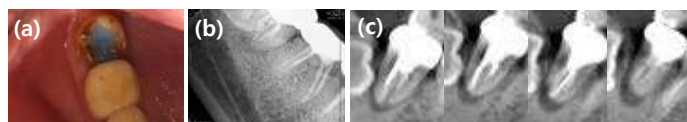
(a) initial intra-oral photograph (b) initial periapical radiograph before the gold crown was exfoliated (c) initial cone-beam computed tomography
